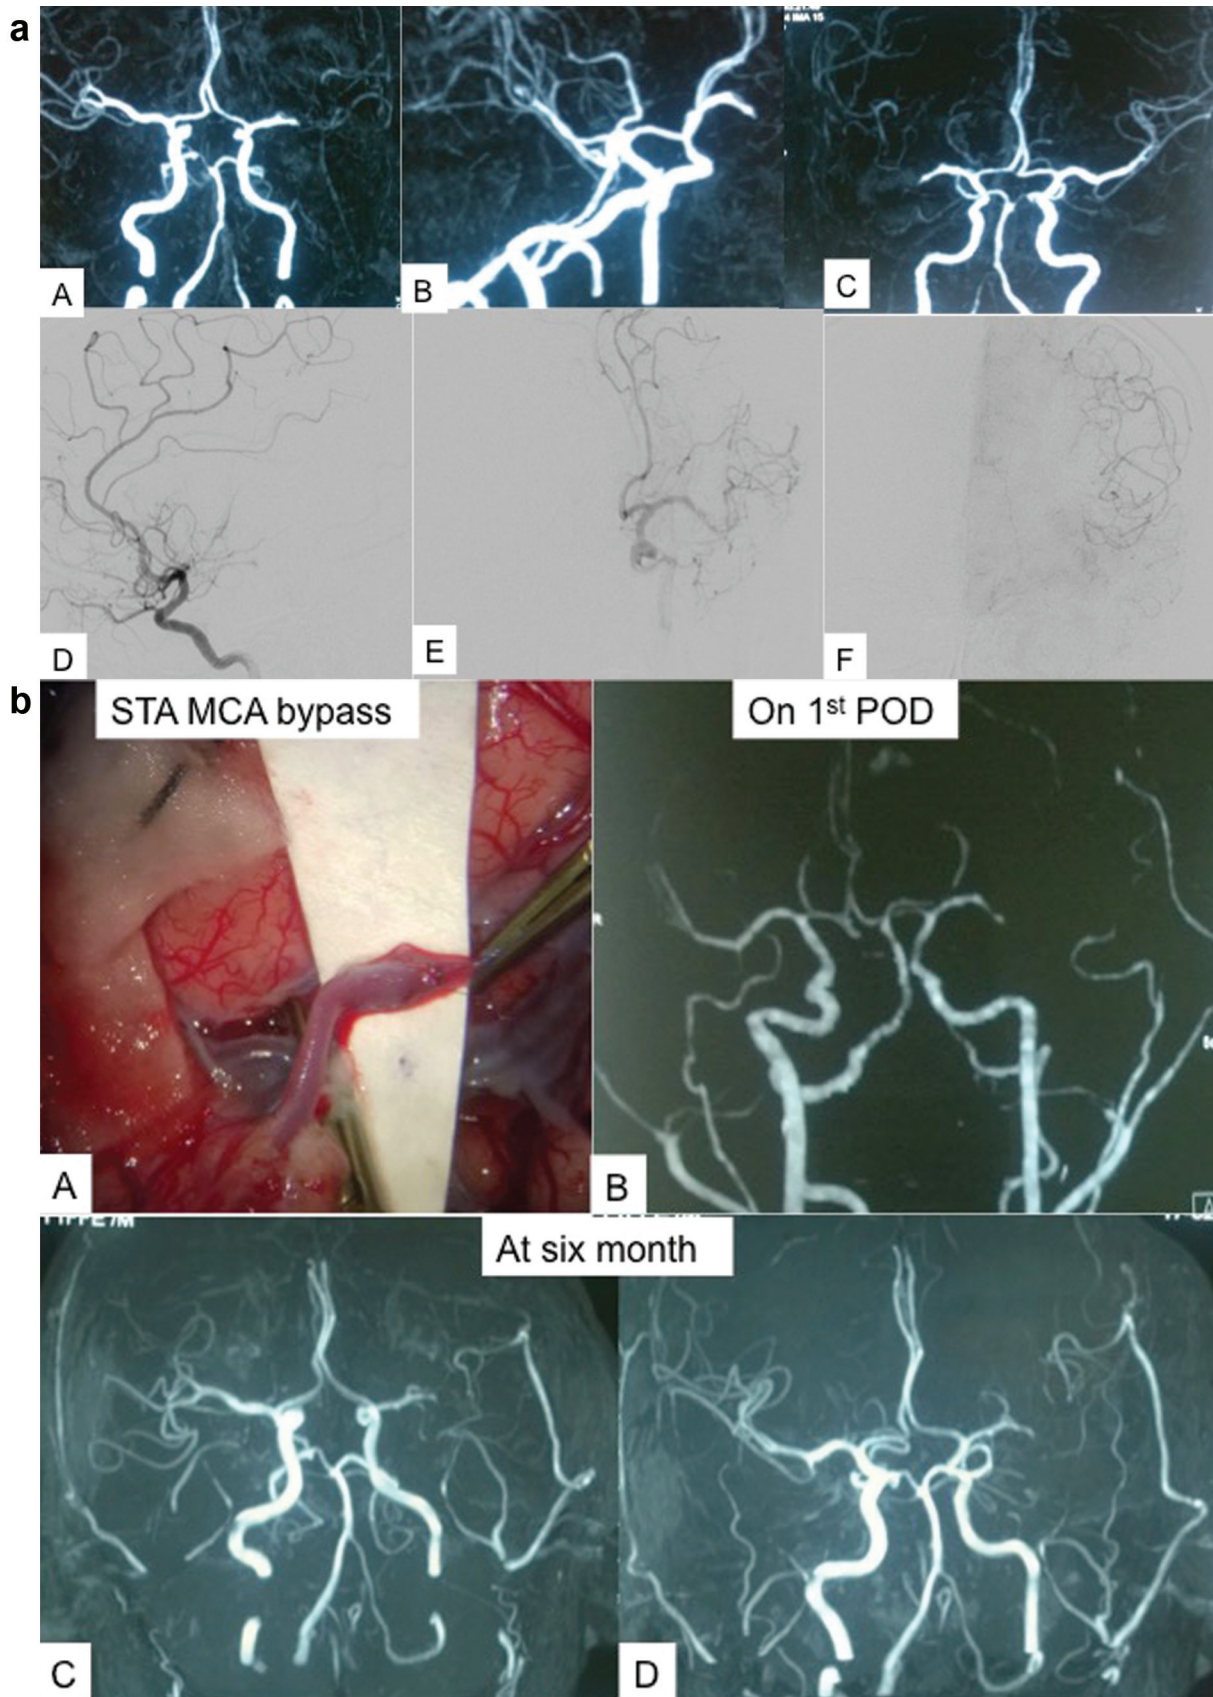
(a): (A, B & C) CTA of the brain showing severe stenosis of the left MCA. (E, F & G) Cerebral DSA showing left MCA stenosis with delayed filling of the MCA territory. (b) (A) Preoperative picture of STA-MCA bypass. (B) CTA of the brain on the 1st POD showing left STA-MCA bypass. (C & D) CTA of the brain 6 months after the operation showing patent STA-MCA bypass.
